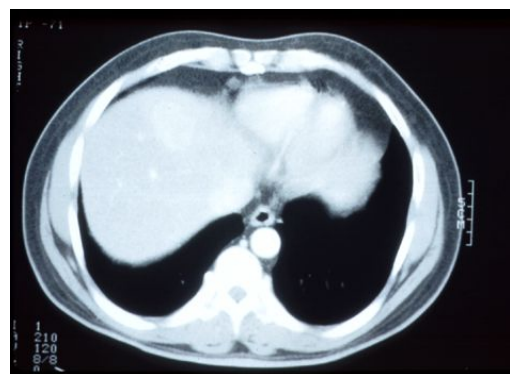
Magnetic resonance image of the upper abdomen of a patient with hepatocellular carcinoma
